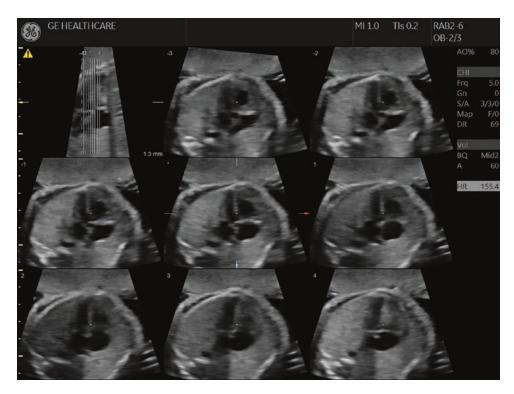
Volumetric ultrasound Tomographic Imaging of Fetal Heart
